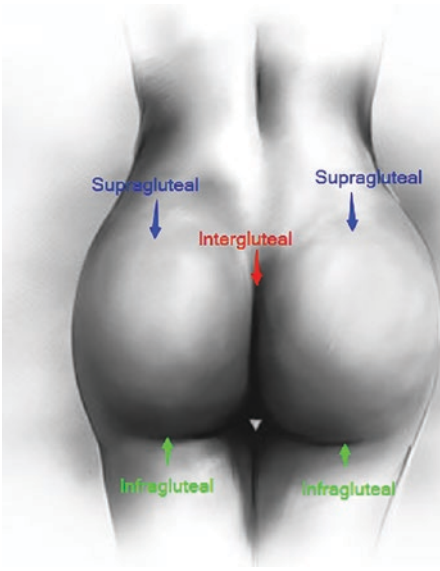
Posterior gluteal access incisions: The supra-gluteal incisions are used for fat harvest of the back, waist, hips, flanks, and sides, as well as fat grafting to the central dome and superior outer hip. The intergluteal incision is used for fat harvest of the back, along the lower latissimus dorsi, and for contouring the superior buttock as well as fat grafting to the dome and the supragluteal region. The infragluteal incisions are used for fat harvest, fat shifting, and fat grafting to the outer hips and thighs. (Reprinted by permission from Springer Nature. ultraBBL: Brazilian Butt Lift Using Real-Time Intraoperative Ultrasound Guidance, by Pat Pazmiño. Copyright © 2020)
